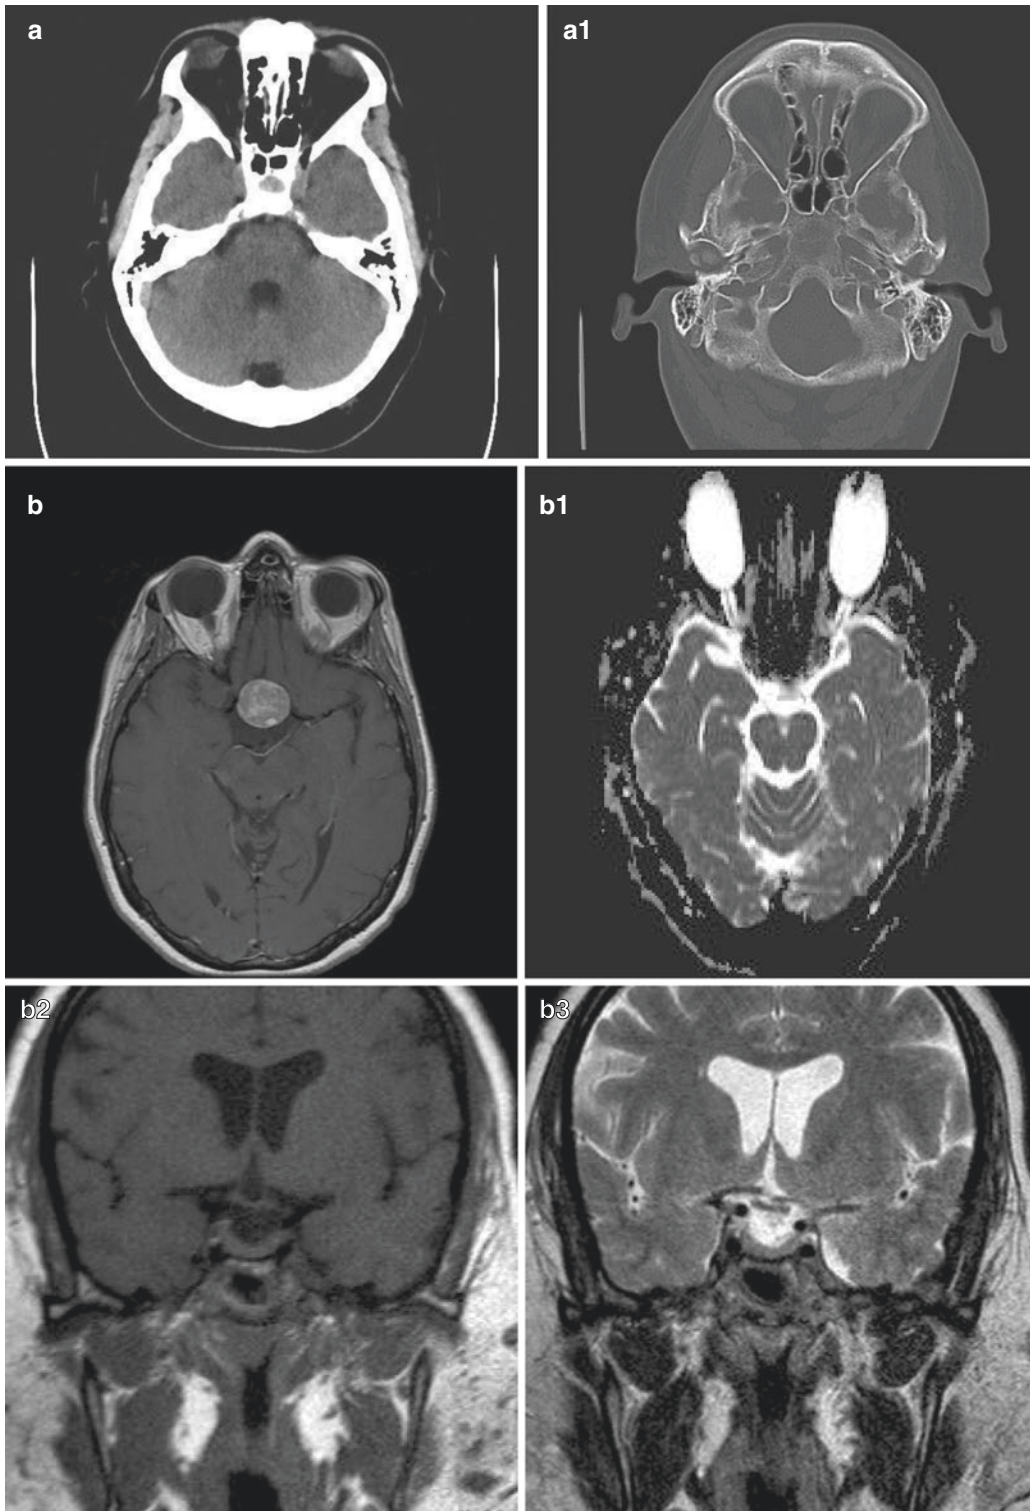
(a and a1). CT and (b) MRI Images. (b) Axial Flair post contrast. (b1) DWI. (b2) Coronal T1 pre contrast (fluid/dark, tissue/white, brain parenchyma/grey).
